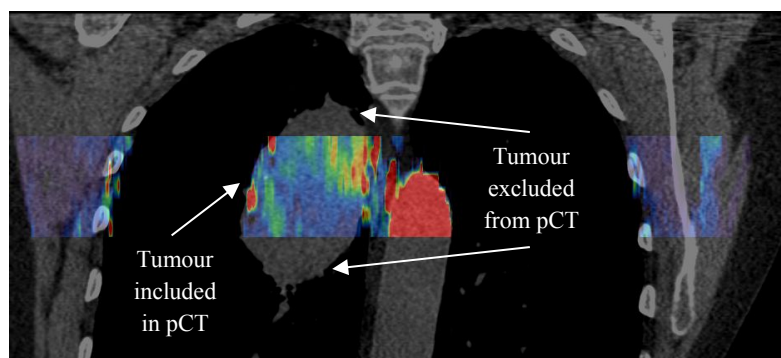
Coronal slice of Patient 5; the section in colour indicates the volume over which the pCT was performed and the underlying greyscale CT is from the pre-contrast CT.
